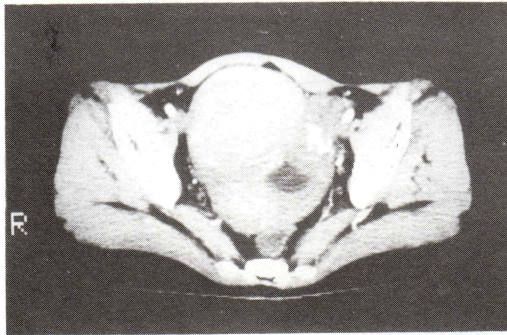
Dynamic CT scan in 45-year-old woman with myoma uteri and 5th week of gestation. A continuous dynamic 5 sec CT scan initiated 14 sec after the beginning of an intravenous bolus injection of the contrast material is shown.
